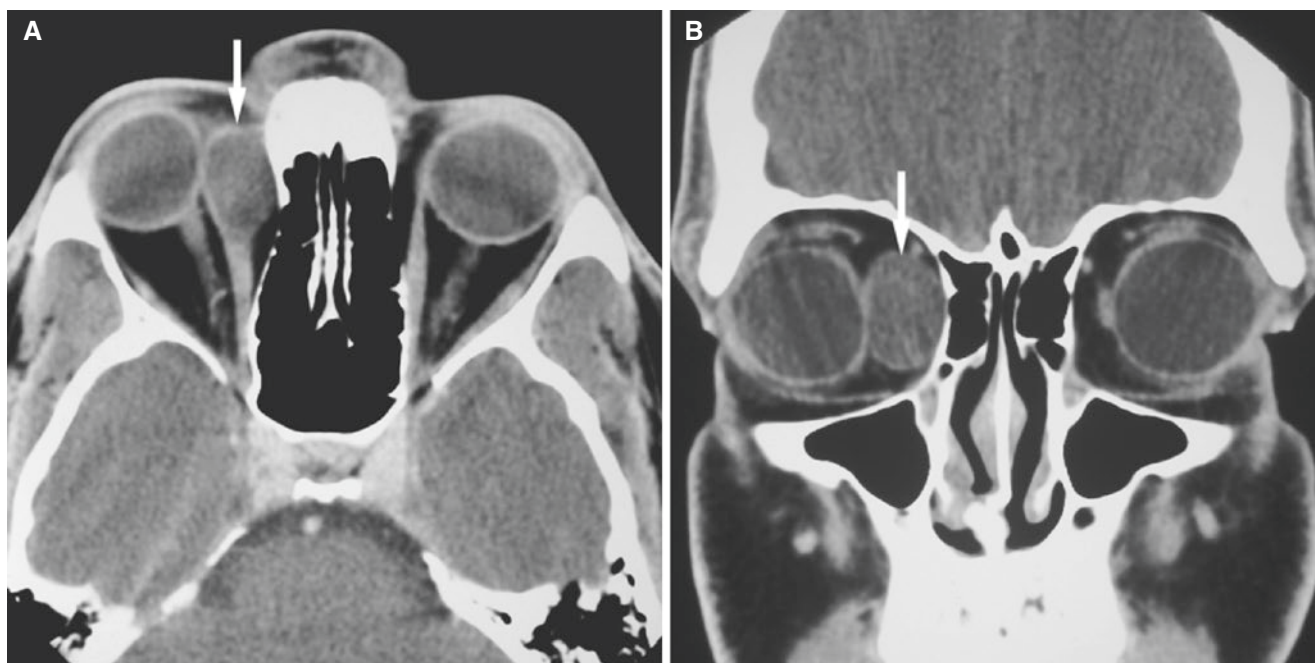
Dermoid; young male with palpable lesion over nasal bridge. Axial (A) and coronal (B) non-contrast CT images show well-demarcated, thin-walled mass (arrows) in supranasal wall of right orbit
